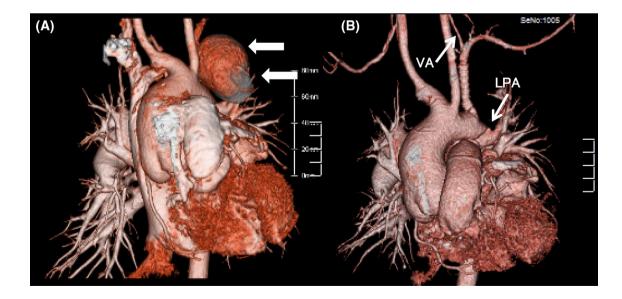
Enhanced 3D computed tomography findings before (a) and after (b) the replacement of left subclavian artery. White arrows indicate pseudoaneurysm. VA vertebral artery, LPA left pulmonary artery
